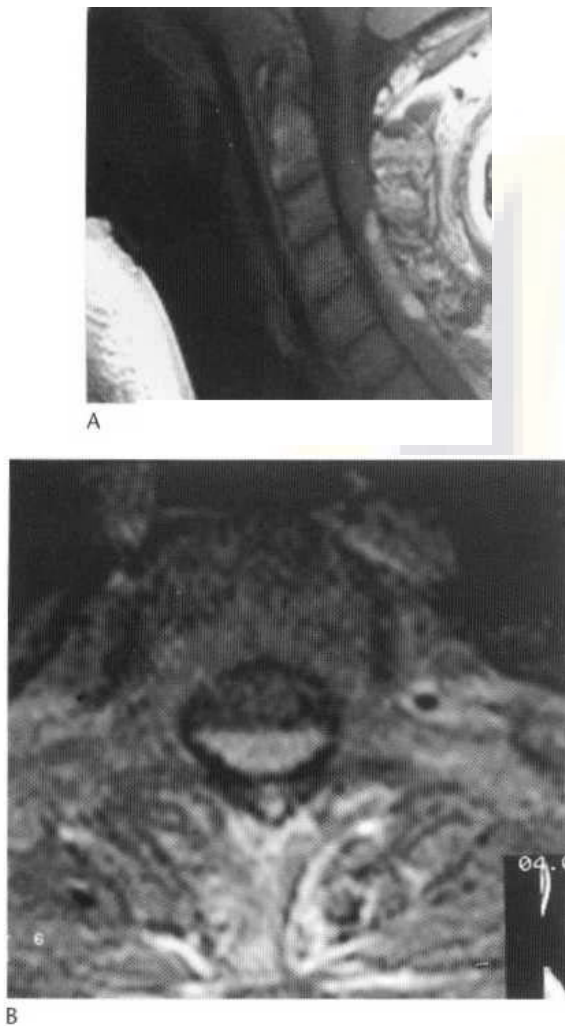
Acute intraspinal haemorrhage. Sagittal (A) and axial (B) MRI with T₁-weighted contrast. The extensive posteriorly located haematoma is well shown. This one probably is subdural in location, and was spontaneous.
